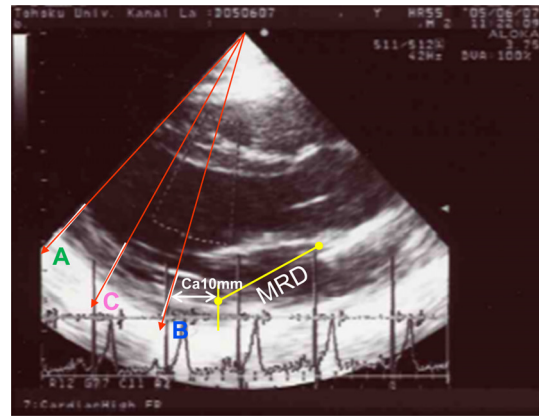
Measurement methods of the structure change of the LV wall by high frame rate 2D echocardiography and of the high-resolution axial strain rate (aSR) by phase difference tracking method. Cardiac structures confirmed by 2D echocardiogram. The 1–3 beam directions to parts A (apical), C (central), and B (basal) were decided on the long-axis section plane. In the aSR method, the beam direction was decided on the systolic maximum image. The received echo signals from the wall for about 6 s were stocked in the digital memory and processed off-line by using our own developed software. The aSR at the point area on the beam was calculated by the bottom equation (strain rate). Details were shown in the previous papers [35,37]. MRD, mitral ring diameter; US beam, ultrasonic beam; LV, left ventricle; End, endo-cardium; Epi, epicardium; $v(x_{1i}; t)$, velocity at the point of x_{1i} ; $v(x_{2i}; t)$, velocity at the point x_{2i} .
